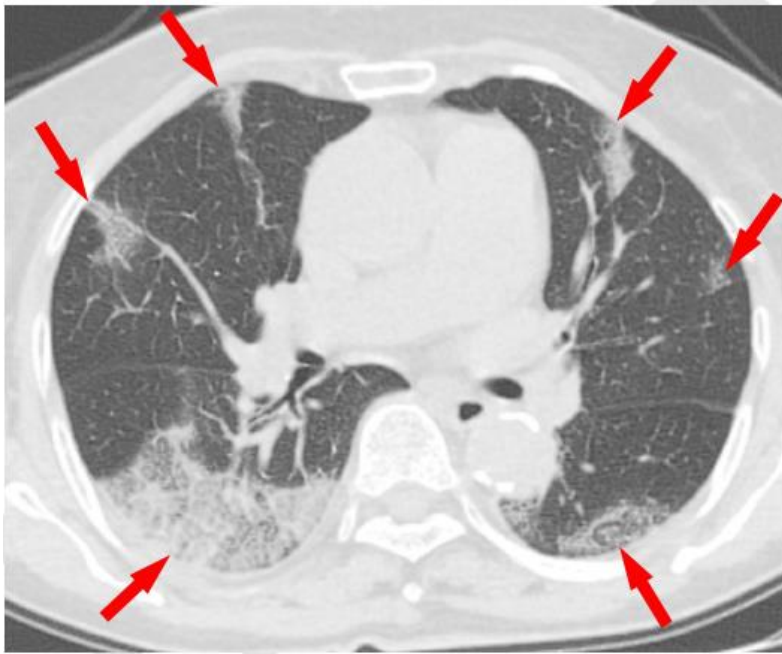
CT findings of confirmed Coronavirus Disease 2019 (COVID-19) pneumonia
